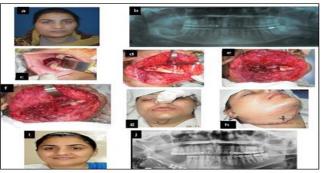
Case of Young female with Ameloblastoma f right side of mandible, Figure-1b) shows pre-operative paronex radiograph, Figure-1c) is the peri-operative image of incision, Figure-1d, e) shows resection of the mandible and defect that is created after resection, Figure-1f) shows mandible reconstruction with vascularized fibula and fixation done with plates, Figure-1g, h) Closure images of the wound showing restoration of the contour, Figure-1i, j) is the two years follow up of the patient showing nice contoured face with good bone union
